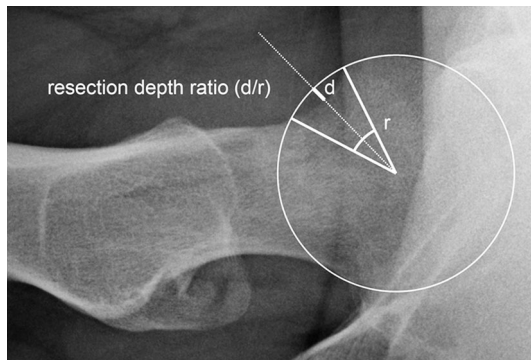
Measurement of resection depth and resection depth ratio on a cross table radiograph
